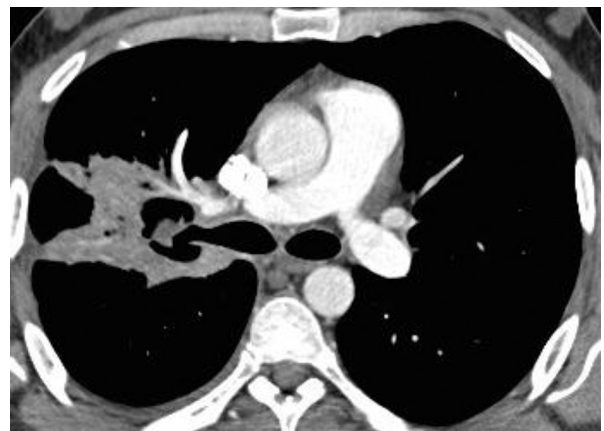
Pulmonary mucormycosis occurred in a 32-year-old patient after induction chemotherapy for acute myeloblastic leukaemia. Enhanced CT scan showed involvement of divided branches of right pulmonary artery by the fungal process. In August 2012, a right upper lobectomy was performed in emergency to prevent the risk of arterial perforation and haemoptysis. Three years later patient is alive and well.
